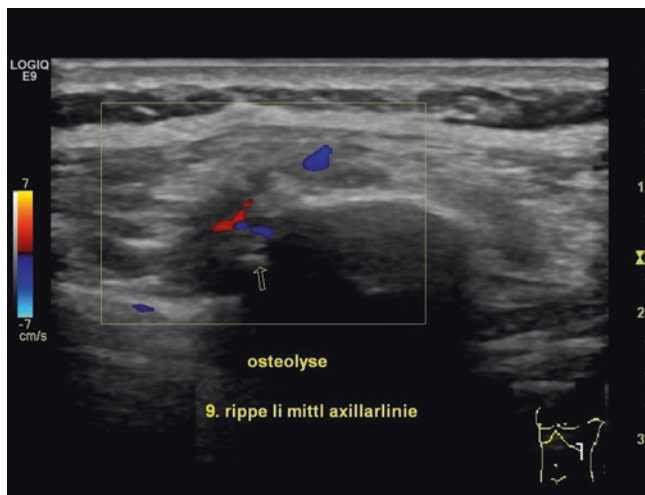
Osteolytic destruction (*arrow*) of the ninth rib (left middle axillary line) in a patient with metastasizing lung carcinoma. Color Doppler depicts small vessels in the tumor
